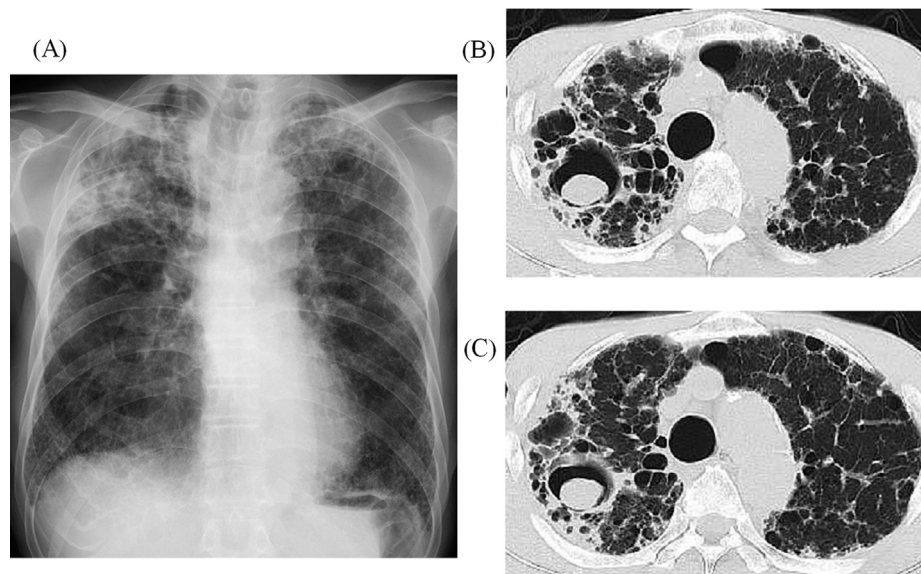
Chest X-ray (A) and CT scan (B, C) obtained at the first visit demonstrated the existence of a fungus ball (longest diameter: 28 mm) in a pulmonary cavity exhibiting idiopathic pulmonary fibrosis-induced traction bronchiectasis.
